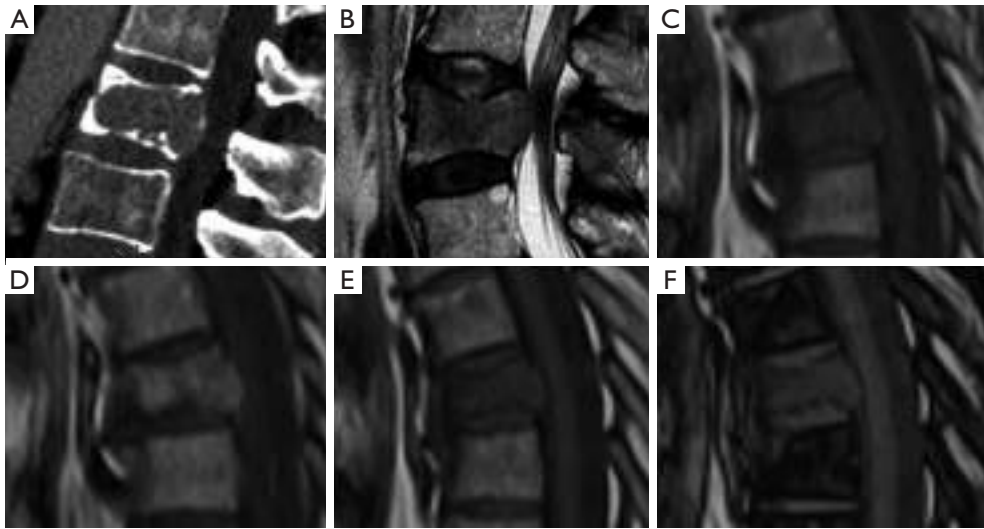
Pathologic fracture in several cases of metastatic lung cancer. Sagittal CT (A) and sagittal T2 weighted images (B) showing convex posterior border. Sagittal T1 weighted image without (C) and with (D) contrast in pathologic fracture. In phase (E) and out of phase (F) showing lack of fat in this metastatic vertebra, with a signal intensity out phase/phase ratio of 0.95. CT, computed tomography.
